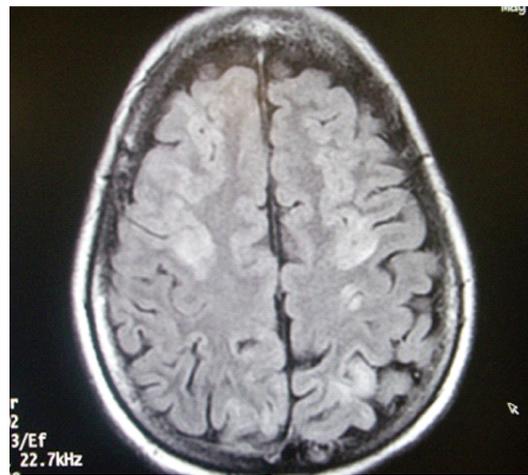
MRI T1W Flair shows brain oedema of posterior frontal and occipital lobe.
